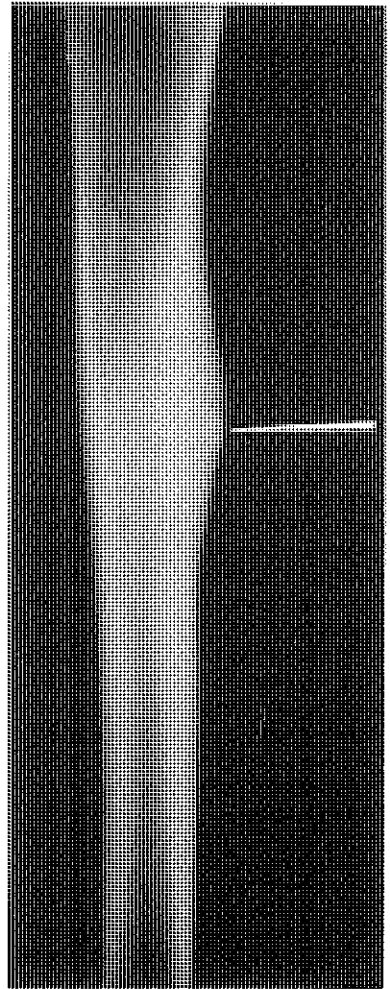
X-ray of the tumor; the arrow shows the "nidus" of the osteoid-osteoma.
